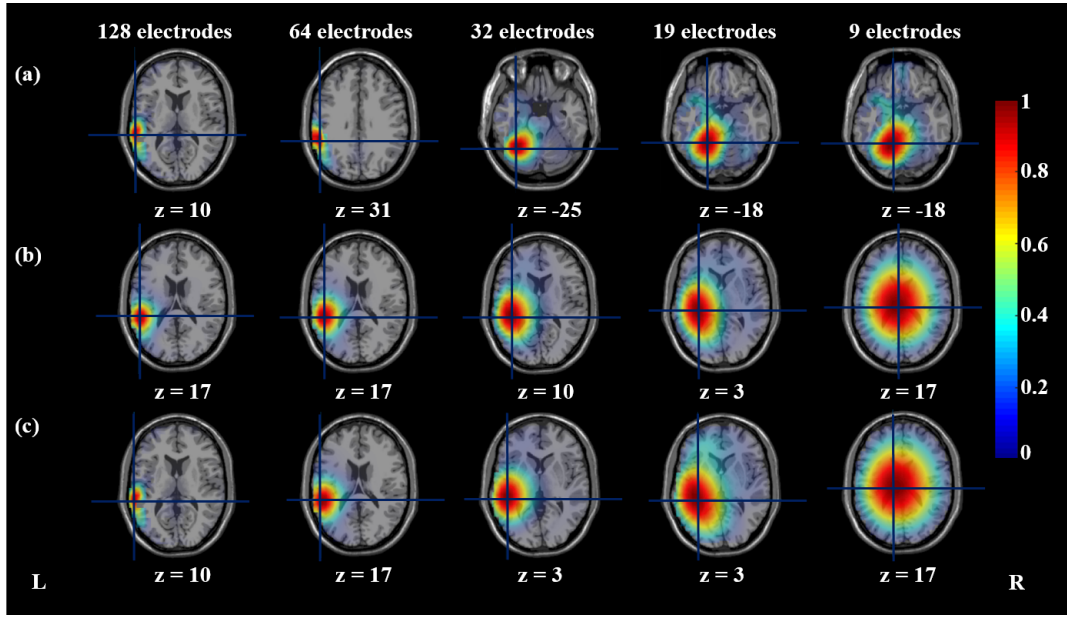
EEG source imaging results via LORETA of a non-averaged spike selected from the EEG dataset, which was generated from the left lateral temporal source with  $5 \text{ cm}^2$  source area. LORETA results using a gray-matter 3D grid and the classical Laplacian matrix are depicted in (a). Results using a full-brain 3D grid and the classical Laplacian matrix are shown in (b). For the results shown in (c), a full-brain grid and the modified Laplacian matrix were used. The results from the 128-, 64-, 32-, 19-, and 9-electrode datasets are shown in columns 1-5 from the left, respectively. The results are visualized as axial MRI slices at each spike's peak, and the cursor is placed at the maximum of the estimated current density. Additionally the z-coordinates of the axial slices are shown in MNI coordinates. The source imaging results were visualized using the Fieldtrip software [OFMS11]
